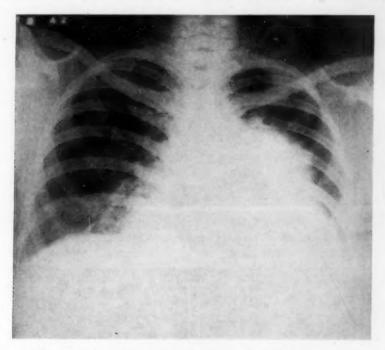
X-ray of the chest in case 7 reveals a marked prominence in the region of the pulmonary artery.
